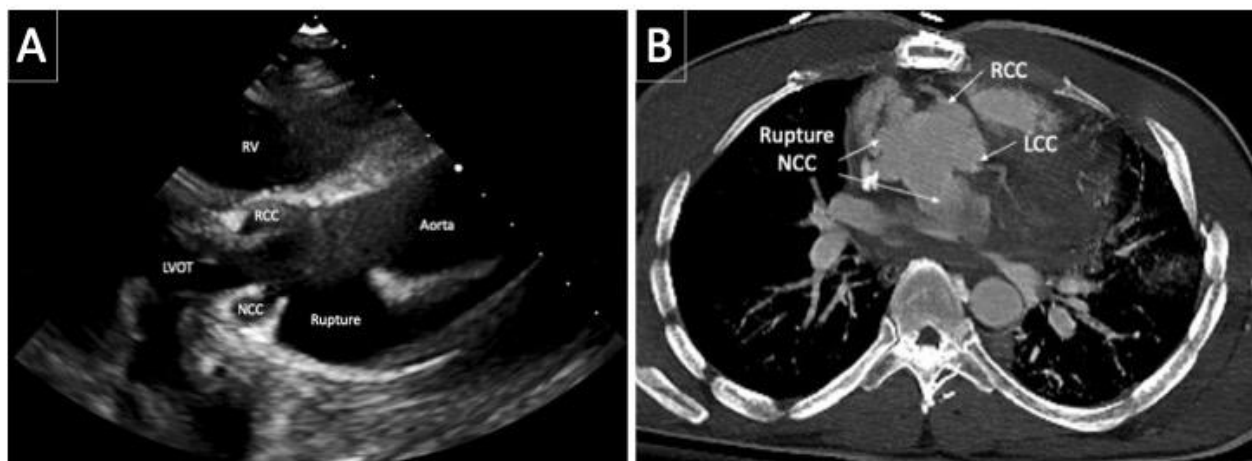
The transthoracic echocardiograph reveals a rupture of the sinus of Valsalva. The rupture is near the aortic root's non-coronary cusp (NCC). Also visible are the right ventricle (RV), left ventricular outflow tract (LVOT), right coronary cusp (RCC), and ascending aorta.
